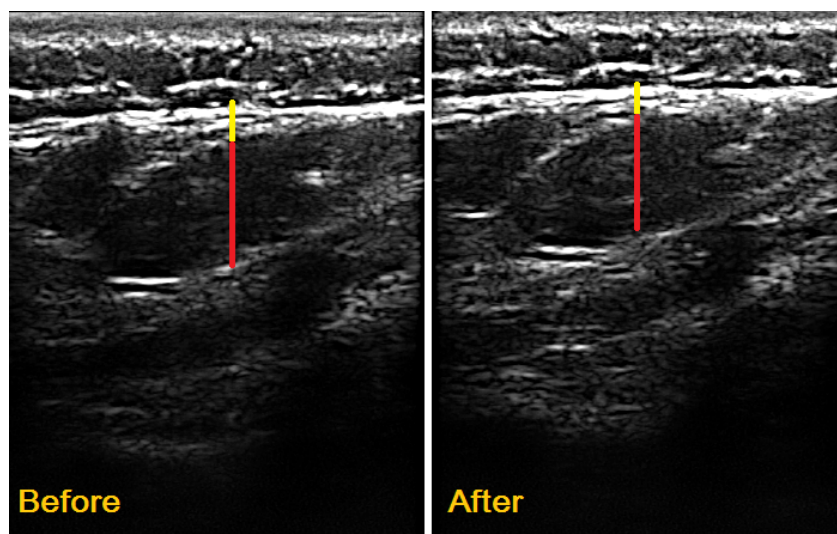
Ultrasonography images before and after the intervention from the lumbar fascia
